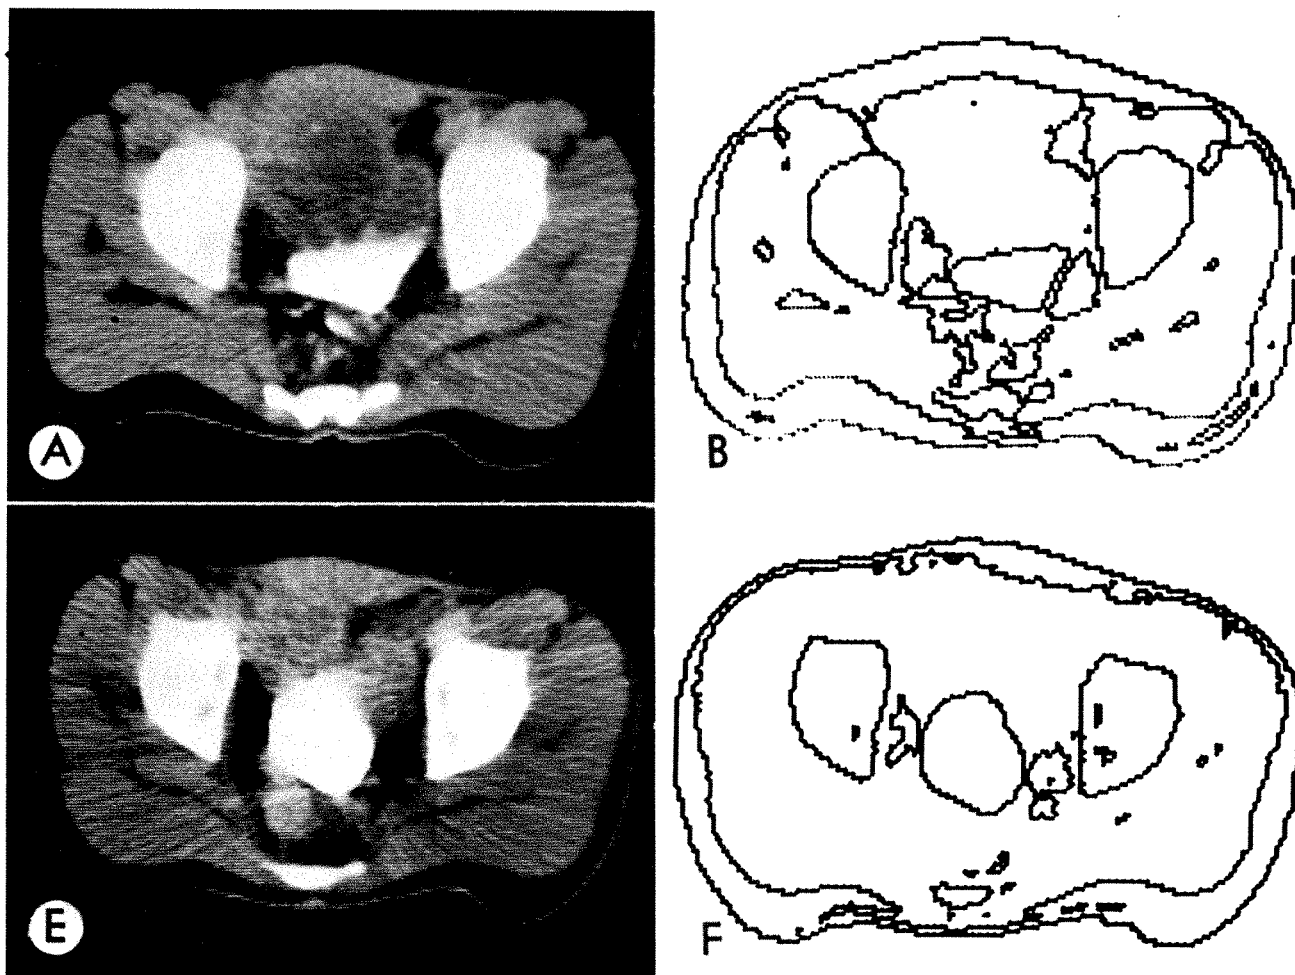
Transitional cell carcinoma of bladder. *A*, CT scan. *B*, Density scan with delineation of tumor. *C*, Computerized scan. *D*, Isodose distribution using anteroposterior parallel opposed portals. *E*, Midtreatment scan with contrast to evaluate progress. *F*, Midtreatment density scan. *G*, Change of treatment plan
